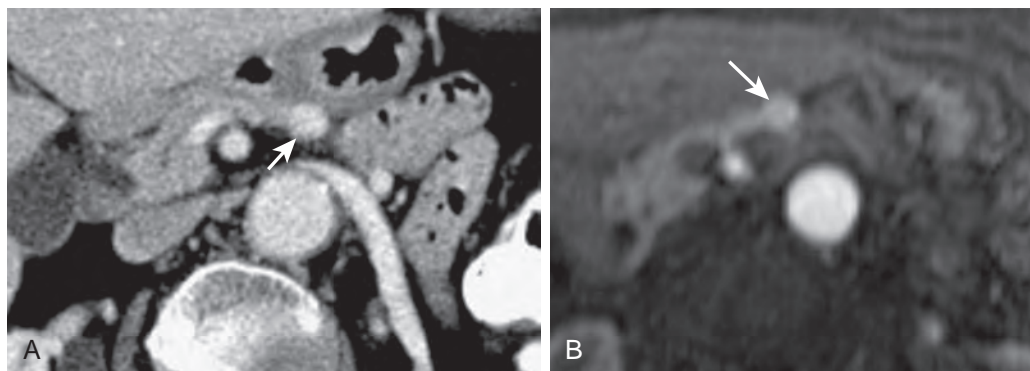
Insulinoma. A. MDCT of insulinoma in a 58-year-old male patient. CT in arterial phase reveals a hyperdense mass (arrow) in the body of the pancreas. The mass appears as bright as the surrounding vessels. B. MRI of insulinoma in the same patient as in A. Arterial phase image from gadolinium-enhanced gradient recalled VIBE sequence again demonstrates the mass in the body of the pancreas (arrow). An insulin-secreting PNET was resected.
